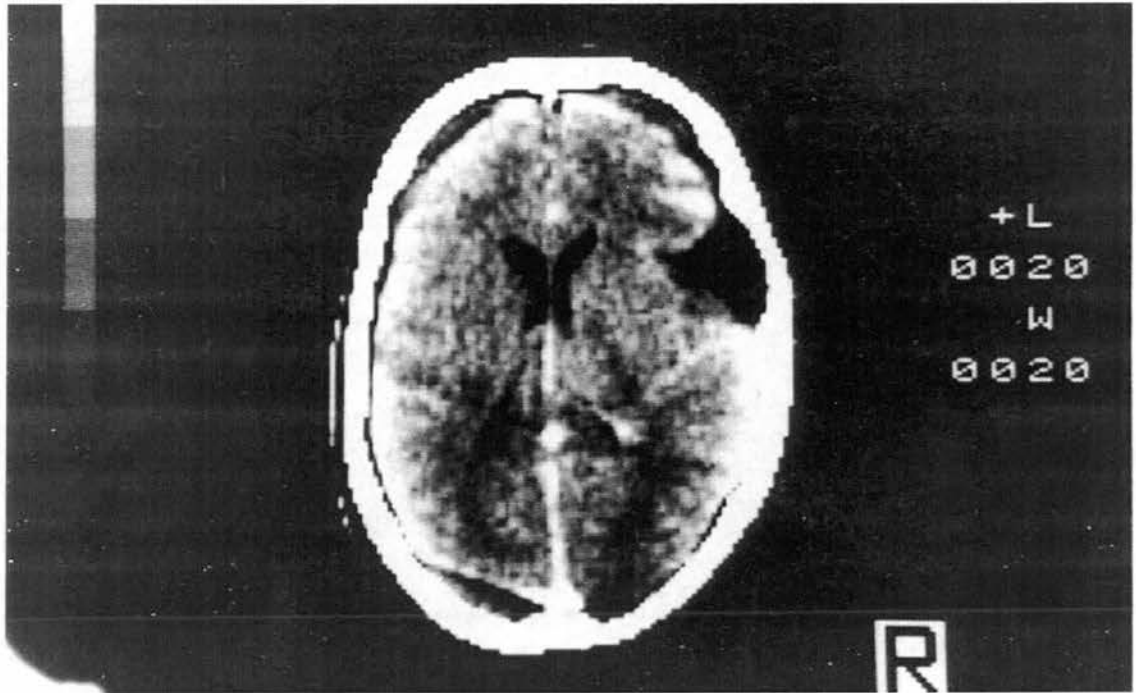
Civ. An image of approximately the same axial slice shown in Figure 1Ciii but acquired using a modern X-ray CT machine. Note the superior spatial resolution.
